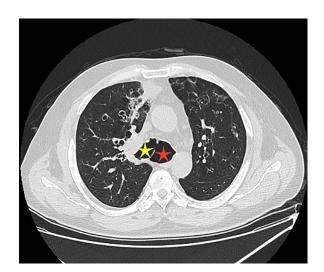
Chest computed tomography in parenchymal window showing dilated right main bronchus measured at 26 mm (yellow asterisk) and left main bronchus measured at 31 mm (red asterisk).
